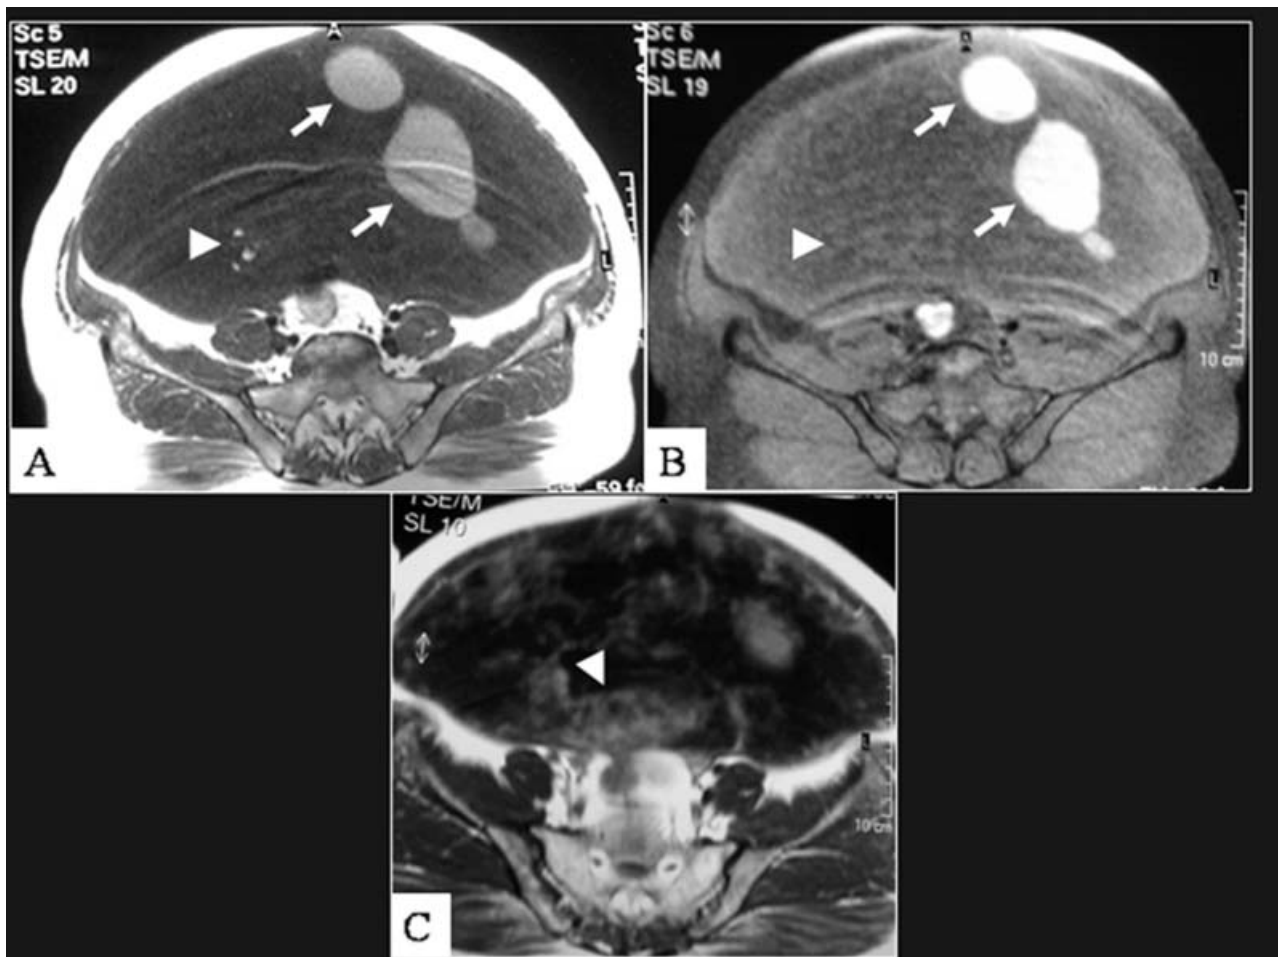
A. Axial T1-weighted image. B. Axial fat-saturated T1-weighted image at the same level as A. These two images demonstrate that areas of high signal intensity on T1-weighted images that do not saturate with a fat-suppression sequence (white arrows) correspond to small areas of high mucin content, and tiny foci of high signal intensity on T1-weighted images that are suppressed on the fat-saturation technique represent foci of fat tissue (white arrow heads). C. Axial T1-weighted MR image after gadolinium administration shows solid enhancing areas (arrow head).
